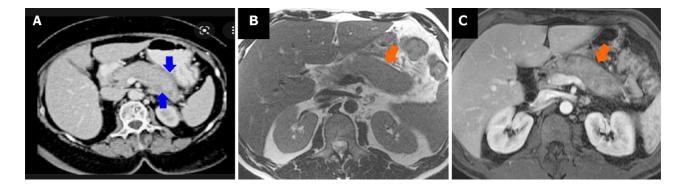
Radiological appearance of autoimmune pancreatitis-part 1. A: Unenhanced computed tomography scan appearance of a diffuse autoimmune pancreatitis (AIP): Sausage-like swelling of the parenchyma, with straight margins, and consequent loss of the typical lobular structure. A hypodense fibrotic capsulelike rim demarcates the swollen pancreas (blue arrow); B: Unenhanced T1 weighted magnetic resonance imaging (MRI) appearance of a diffuse AIP: Sausage-like swelling of the parenchyma, with straight margins, and rectangular shape of the tail (cut-tail sign) (orange arrow); C: Arterial phase of the contrast-enhanced T1 weighted MRI: Homogeneous reduced enhancement of the pancreatic parenchyma, with a more hypointense fibrotic capsule-like rim that demarcates the swollen pancreas (orange arrow).
